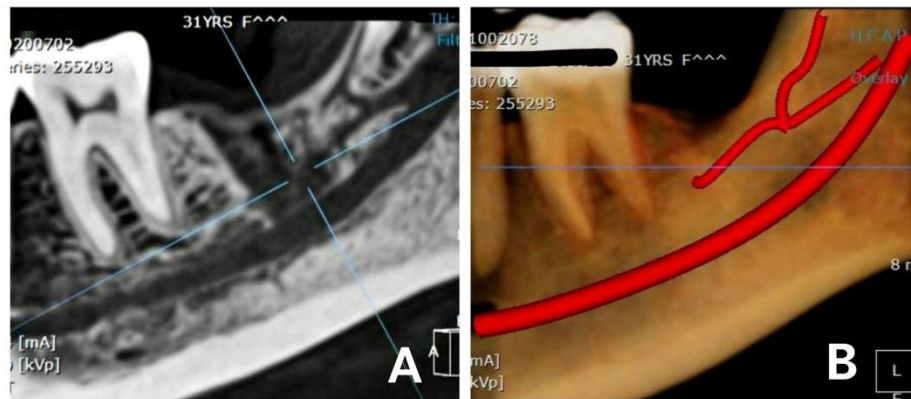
Post-operative CBCT of case 1 showing Type B2 retromolar canal.
